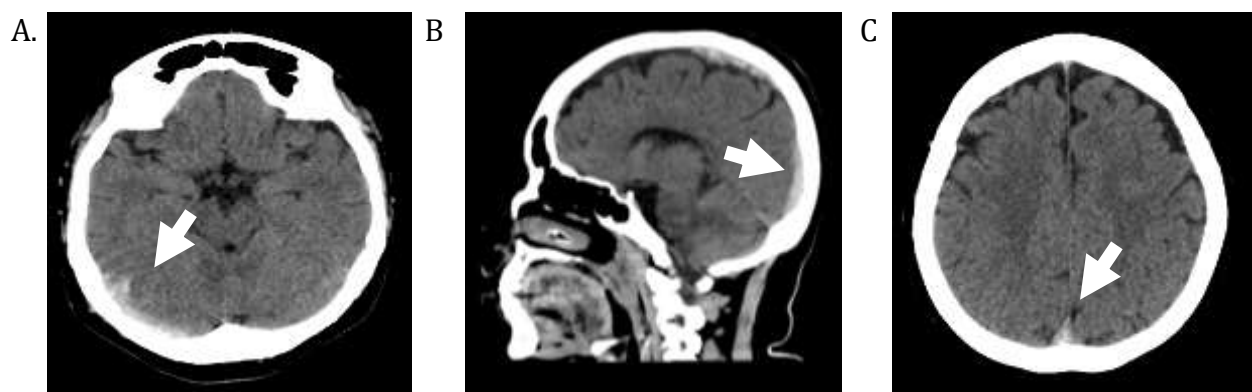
Non-contrast Head CT scan
